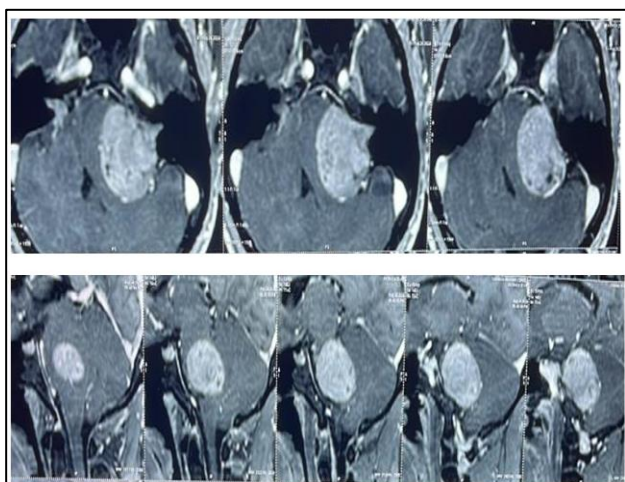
MRI with contrast showing a grade 4 vestibular schwannoma with brainstem compression.
